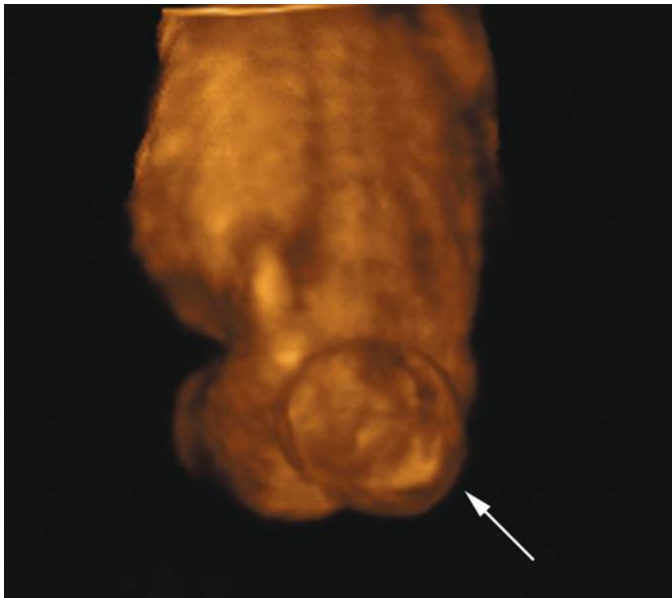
Three-dimensional sonogram showing the fetal back affected by a neural tube defect (arrow) in the lumbosacral area.
